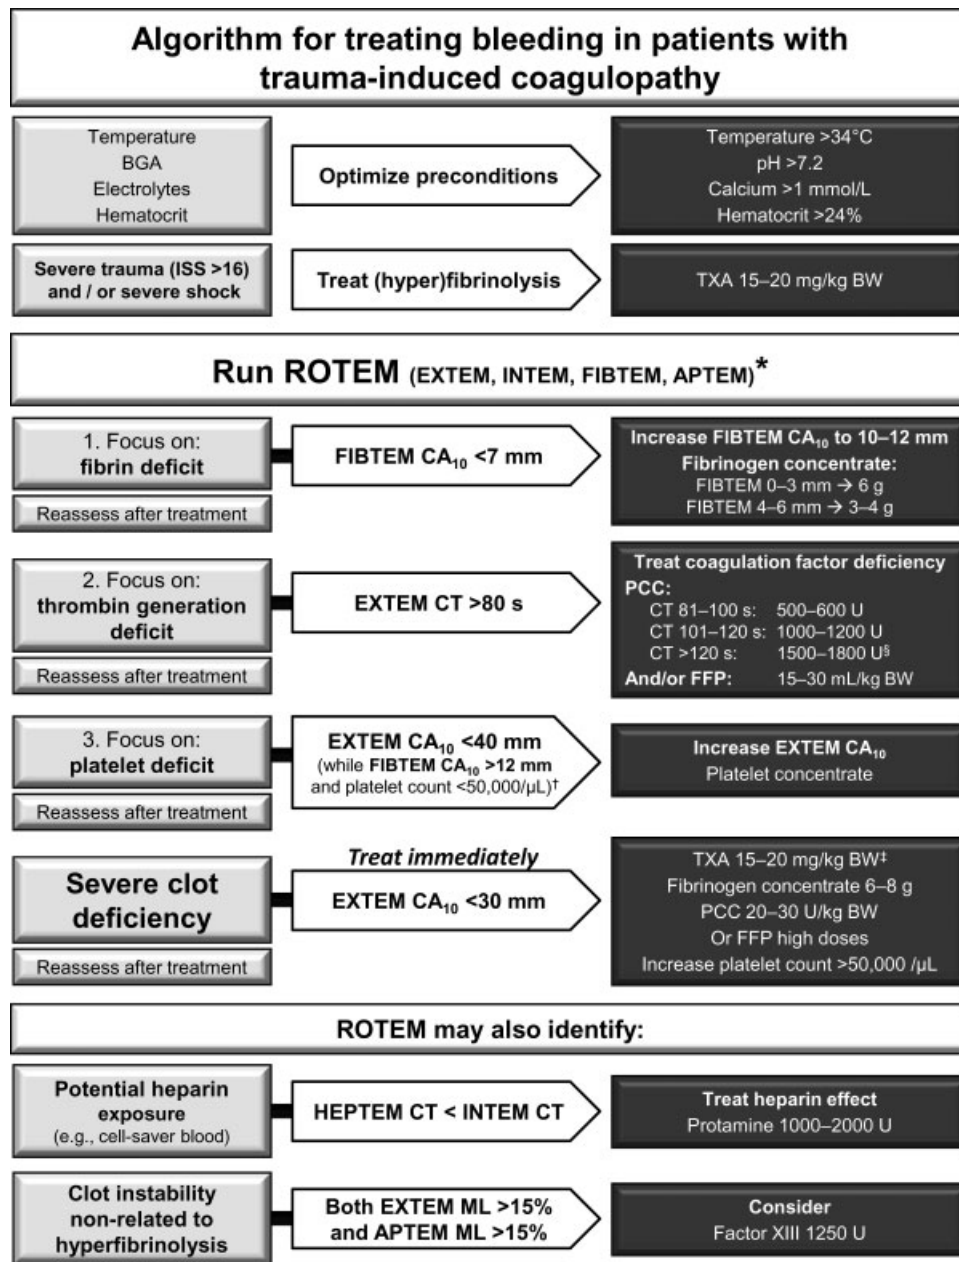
Algorithm for managing trauma-induced coagulopathy and diffuse microvascular bleeding. *For patients who are unconscious or known to be taking platelet inhibitor medication, Multiplate tests (adenosine diphosphate test, arachidonic acid test, and thrombin receptor activating peptide-6 test) are also performed. [§]If decreased antithrombin III (ATIII) is suspected or known, consider coadministration of ATIII. [†]Any major improvement in extrinsically activated test plus aprotinin or tranexamic acid (APTEM) parameters compared with corresponding EXTEM parameters may be interpreted as a sign of hyperfibrinolysis. [‡]Only for patients not receiving TXA at an earlier stage of the algorithm. BGA, blood gas analysis; BW, body weight; Ca, calcium; CT, clotting time; FFP, fresh frozen plasma; ISS, injury severity score; ML, maximum lysis; PCC, prothrombin complex concentrate; TXA, tranexamic acid. (Reproduced with permission from Schöchl H, Schlögl C. Trauma bleeding management: the concept of goal-directed primary care. *Anesth Analg* 2014;119(5):1064–1073.)
